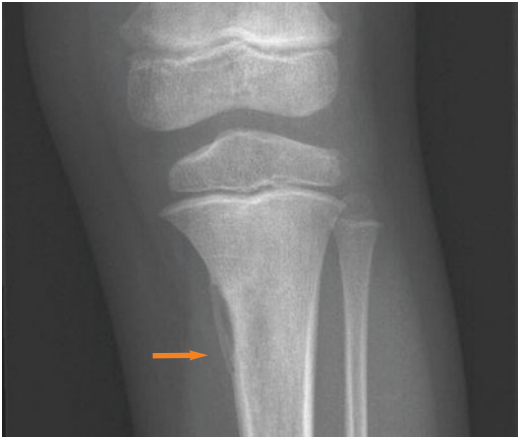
Anteroposterior X-ray of the left knee. Subperiosteal abscess on the medial side in the proximal part of the tibia (*arrow*)
